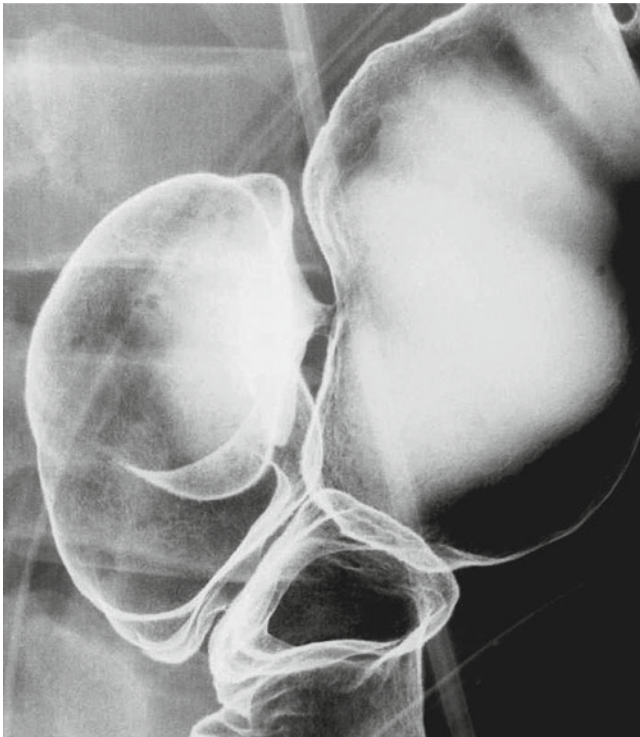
Radiographic findings of the site of stenosis revealed by endoscopy. EBD was performed at a later date, after the endoscope was unable to be passed through. After EBD, the endoscope did pass through, enabling endoscopic observation of the proximal side
